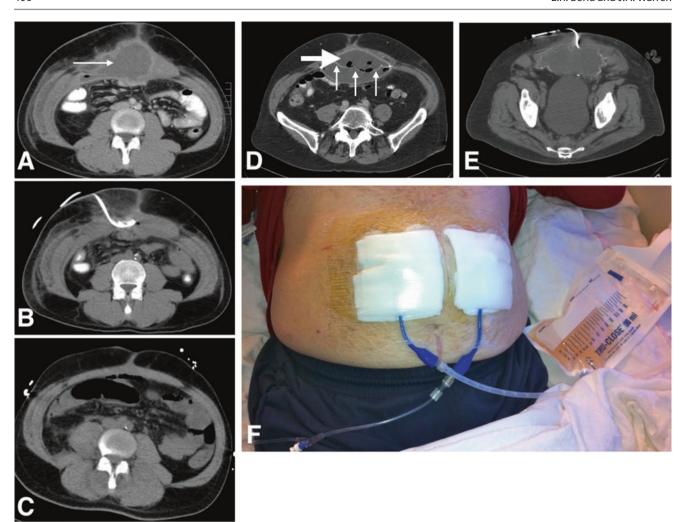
(a) CT demonstrating periprosthetic SSI (*arrow*) after retromuscular repair with large-pore PP. (b) Percutaneous drainage of deep SSI. (c) Resolution of mesh infection at 3 months. (d) CT demonstration
